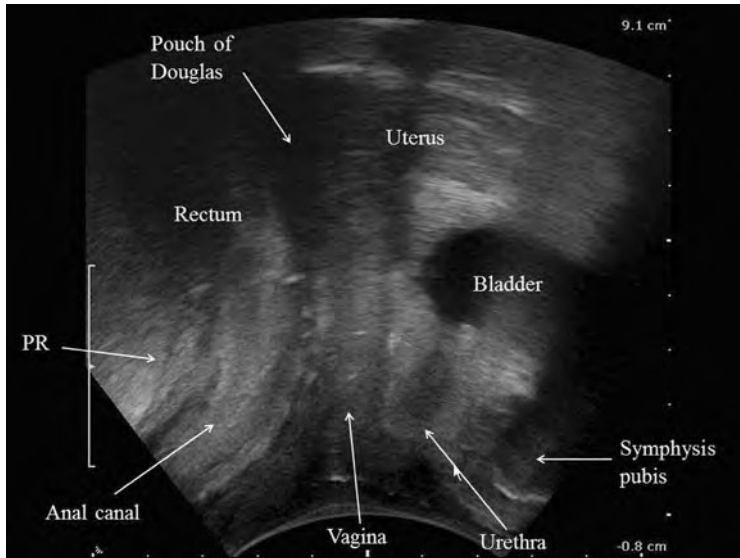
Two-dimensional transperineal ultrasonography. Midsagittal view of normal female pelvic floor, including the symphysis pubis, the urethra and bladder, the vagina and uterus, the rectum, and the anal canal. Posterior to the anorectal junction, the puborectalis (*PR*) muscle is visualized as a hyperechogenic structure
